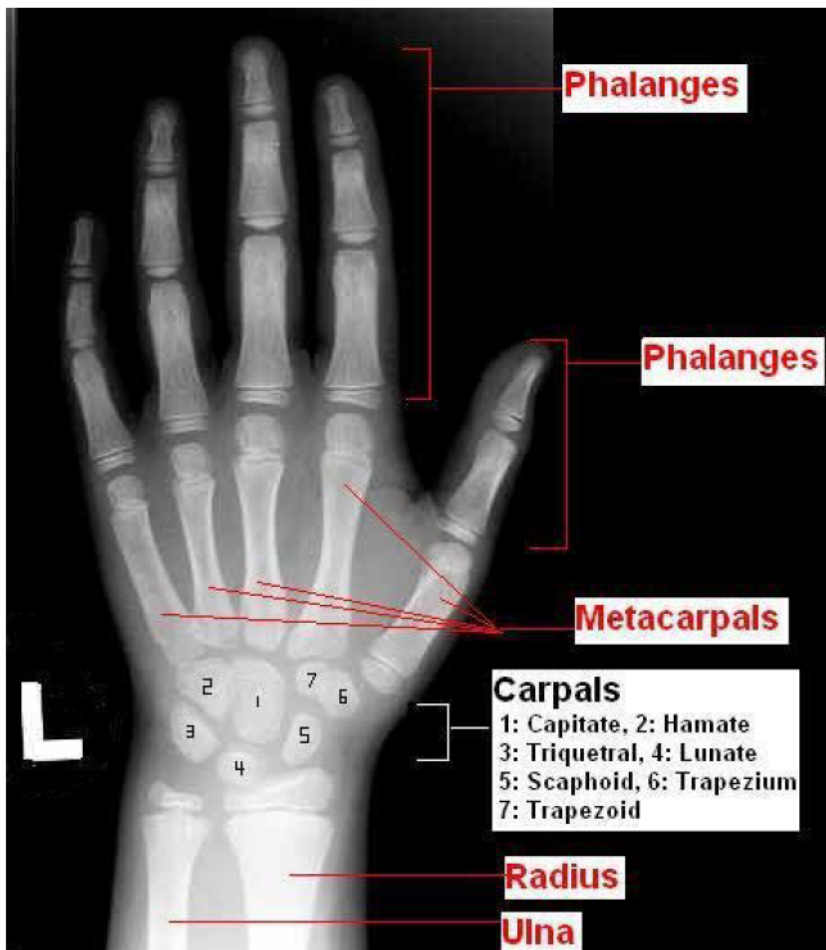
Radiographic image showing the anatomy of the hand
